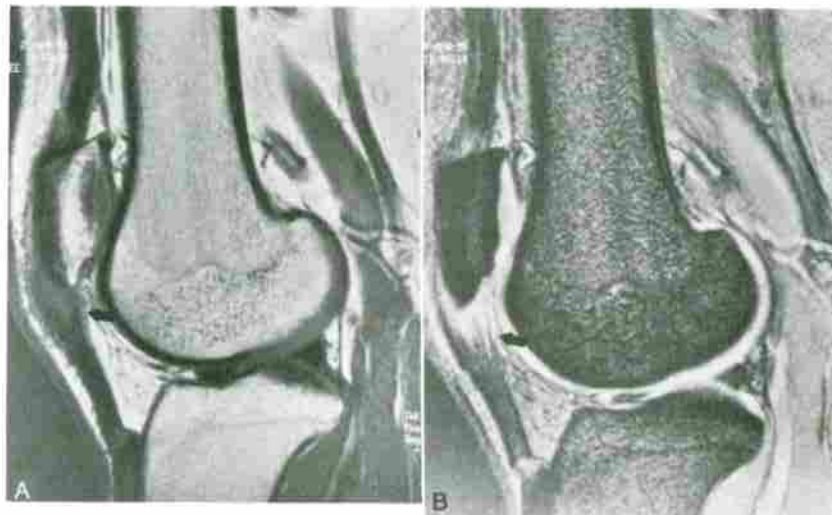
Jumper's knee. A, Sagittal T1-weighted (TR/TE, 430/20) and (B) corresponding gradient-echo (TR/TE, 442/18; angle, 30 degrees) images demonstrate abnormal thickening and high signal intensity in the proximal patellar tendon from partial tears (arrow).
